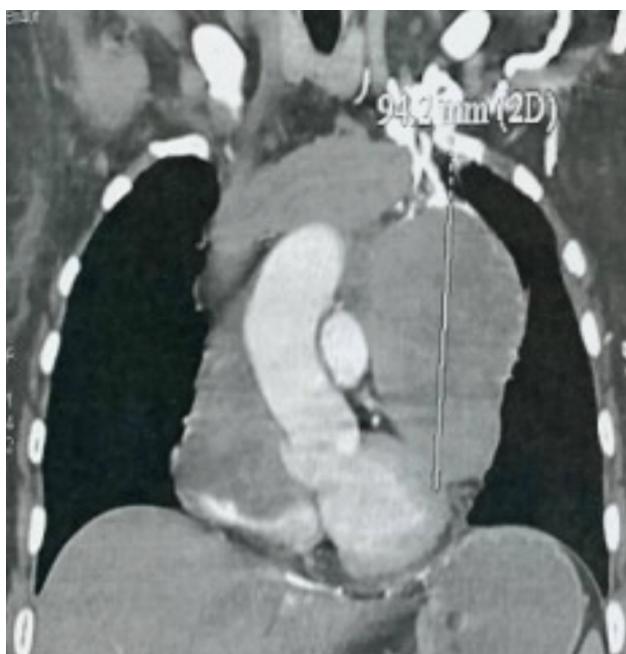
CT scan of a 57-year-old lady who presented with buffy face showing malignant thymoma invading the SVC with propagating thrombus to the right atrium.
